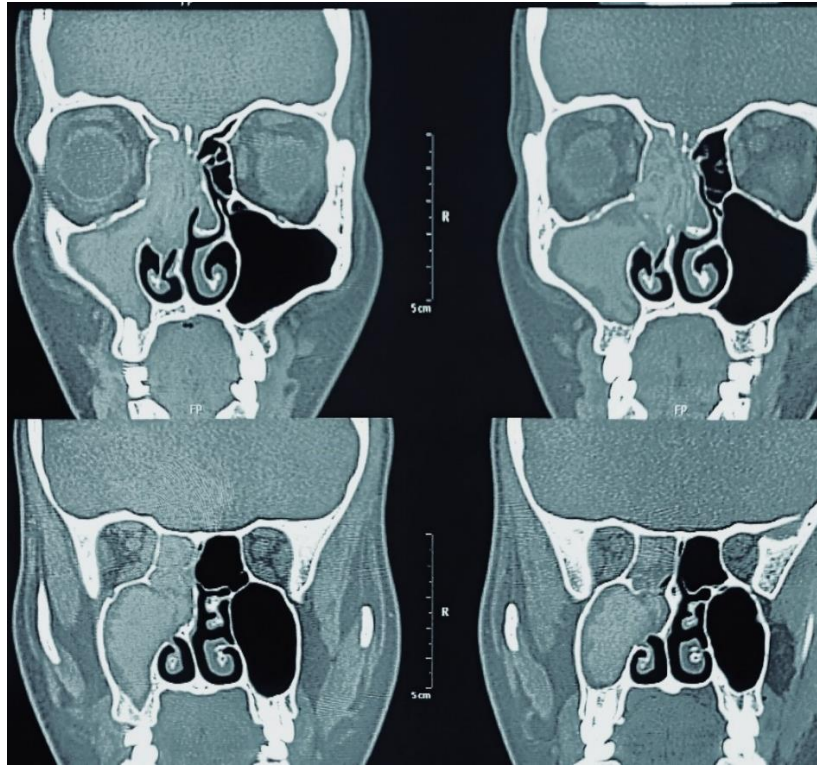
Coronal noncontrast CT imaging from a patient with AFS. Expanded right maxillary antrum, right ethmoidal complexes. They show complete inhomogeneous opacification with hyperdense material is seen located centrally surrounded by hypodense mucosa
